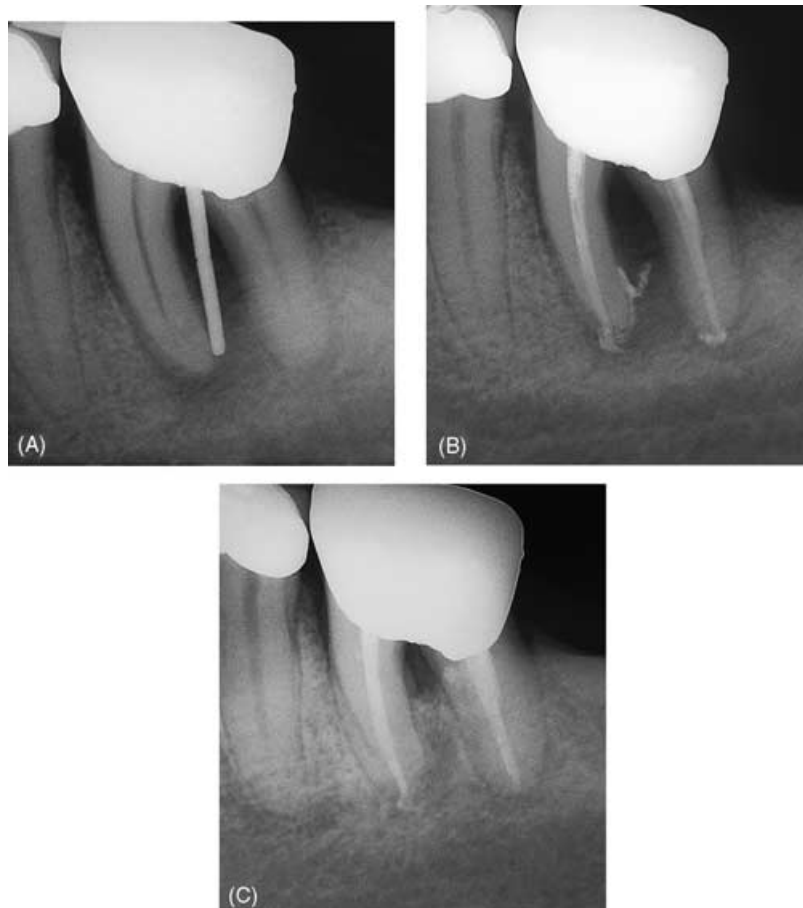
Primary endodontic disease with secondary periodontal involvement in a mandibular first molar. (A) Preoperative radiograph demonstrating interradicular defect extending to the apical region of the mesial root. (B) Radiograph taken upon completion of root canal therapy. (C) One year follow-up radiograph showing resolution of most of the periradicular lesion, however, a bony defect at the furcal area remained. Note that endodontic treatment alone did not yield complete healing of the defect. Periodontal treatment is necessary for further healing of the furcal area and inflamed gingival tissues.
